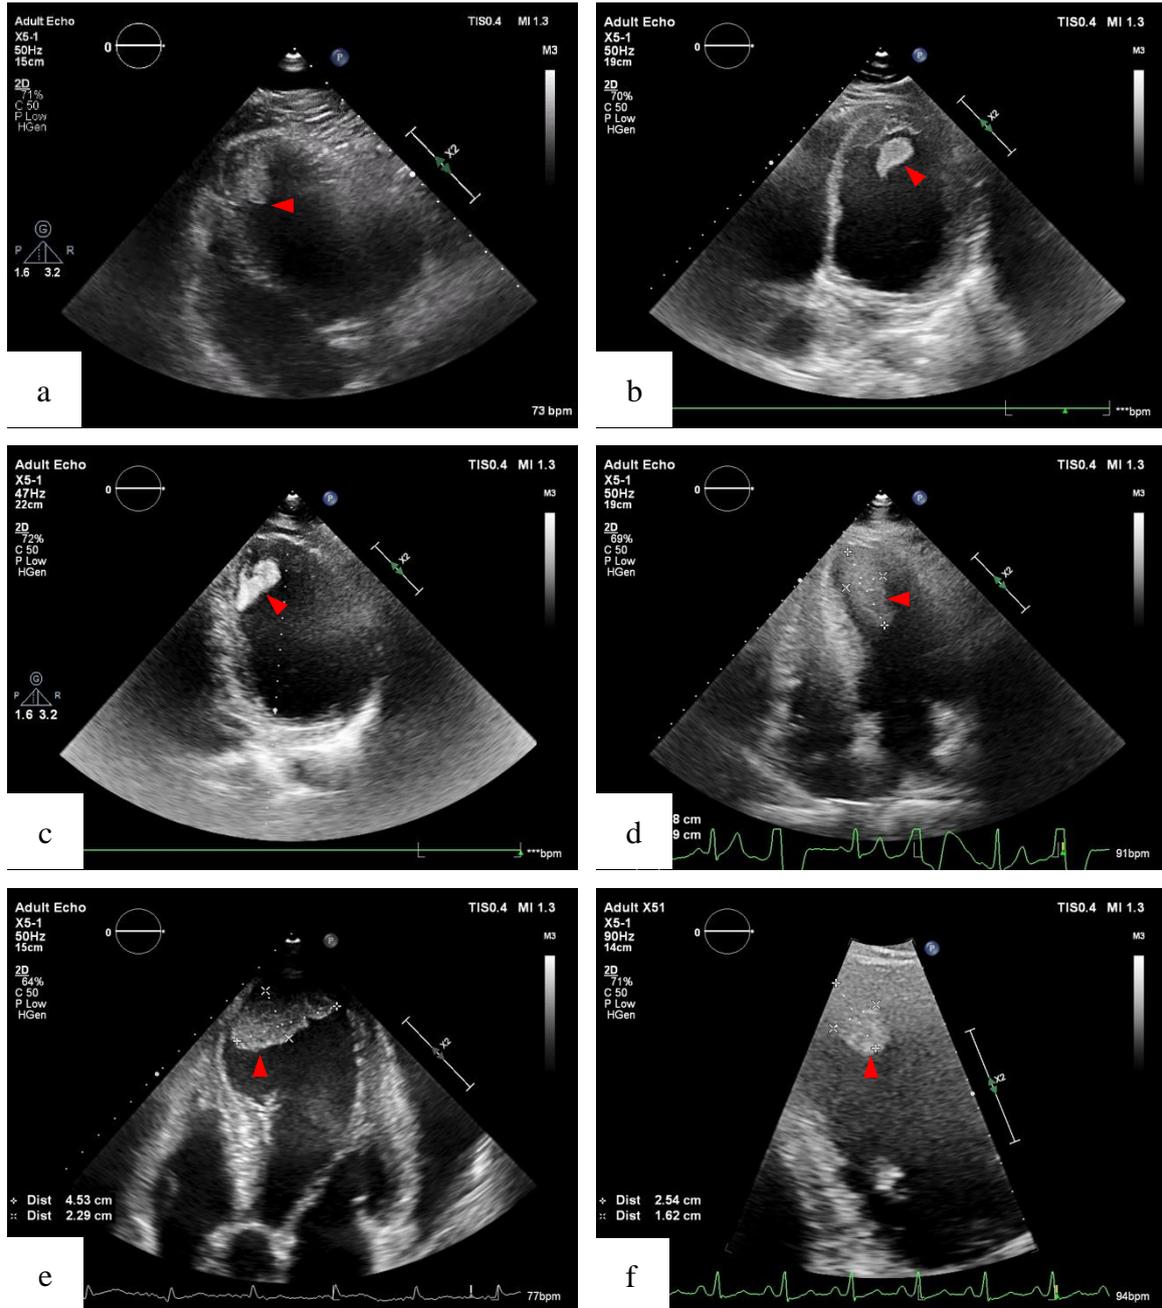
Transthoracic echocardiography (TTE) performed in reported patient (a) and five others (b-f) revealing left ventricular (LV) thrombi of different shapes and sizes (red arrows). Although giving clear picture of location and morphology, this imaging method does not allow one to assess nature of the mass, and thus its etiology. (Authors' own material).
